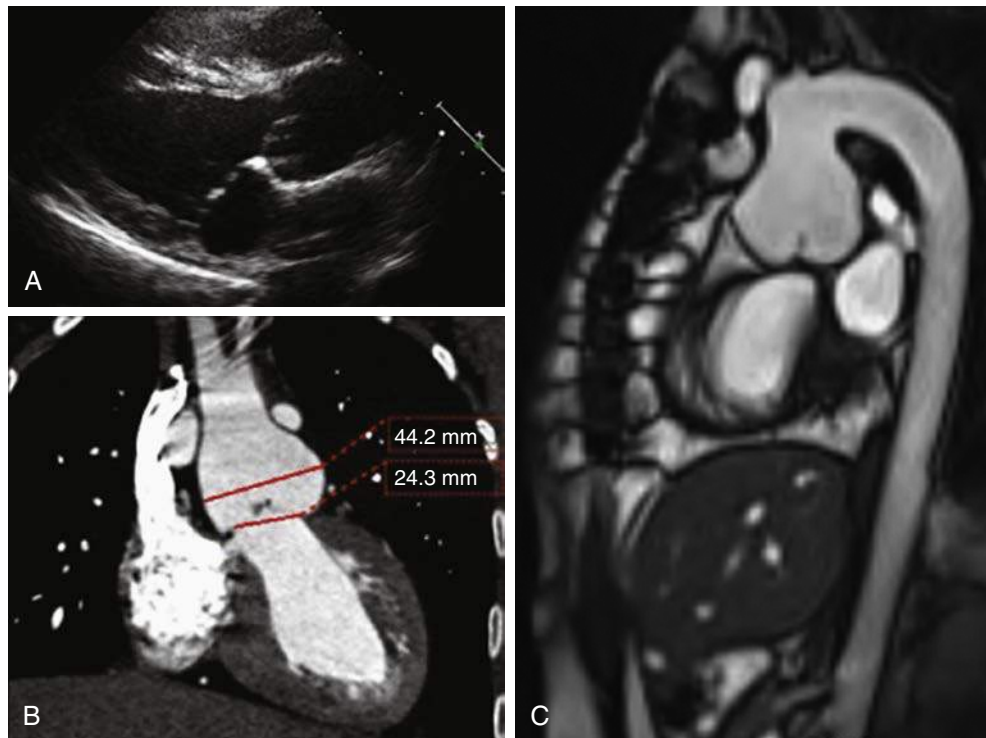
Echocardiogram (A), Computed tomography imaging (B), and cardiac magnetic resonance imaging (C) of a 33-year-old female with transposition of the great arteries who had undergone a neonatal arterial switch. In 2001 the right ventricular outflow tract was reconstructed; she is currently being followed for a dilated neo-aortic root.
